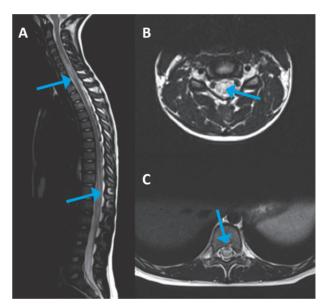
A. Sagittal T2-weighted image showing two hyperintense medullary lesions at C4-T1 and T10-L1 levels (arrows), with swelling of the spinal cord. B. Axial T2-weighted image at the level of C6 showing an eccentric lesion (arrow). C. Axial T2-weighted image at the level of L1 demonstrating a centrally located lesion, with increased signal intensity occupying more than two thirds of cross-sectional area of the cord (arrow). No abnormal enhancement was observed after gadolinium intravenous administration (images not shown).
